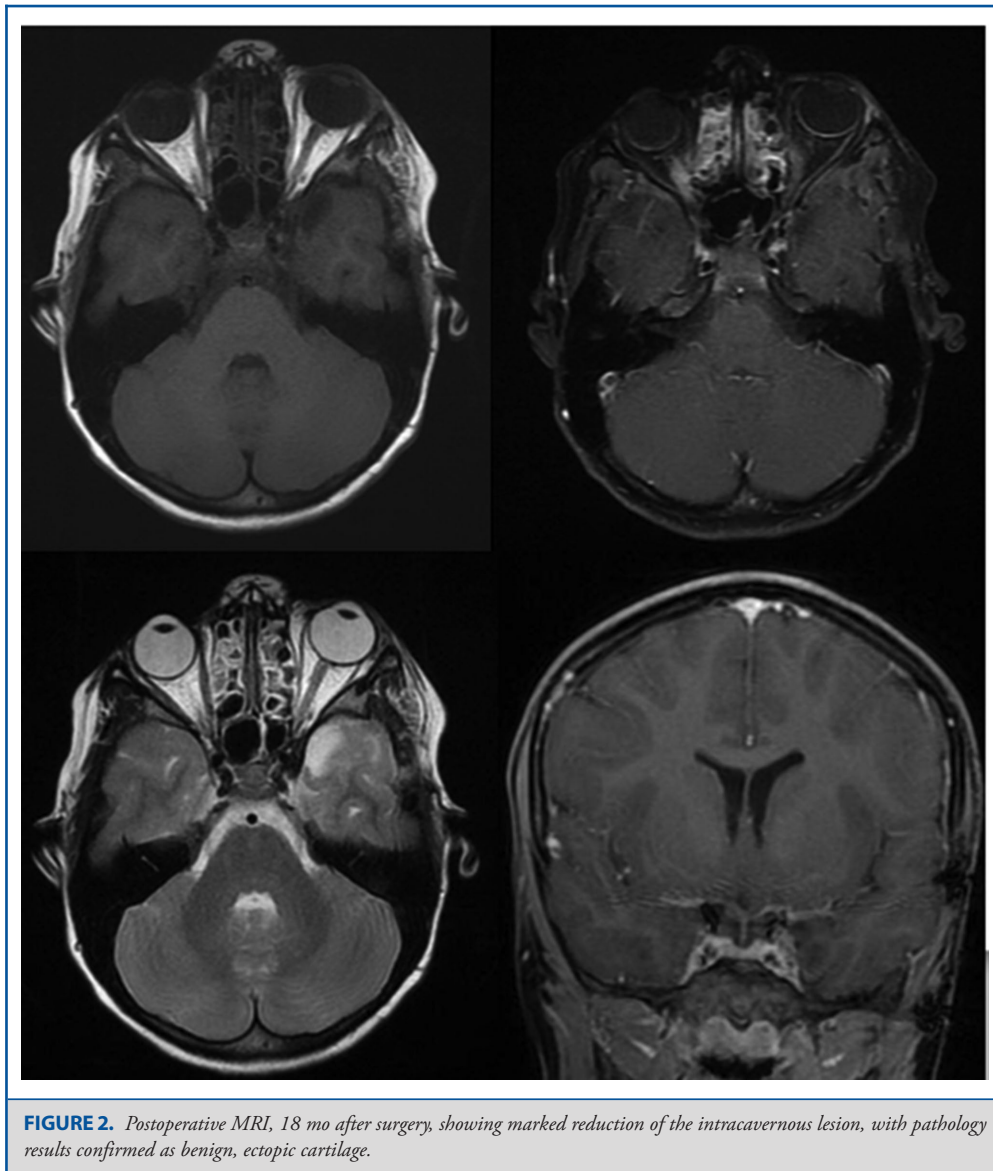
Postoperative MRI, 18 mo after surgery, showing marked reduction of the intracavernous lesion, with pathology results confirmed as benign, ectopic cartilage.
